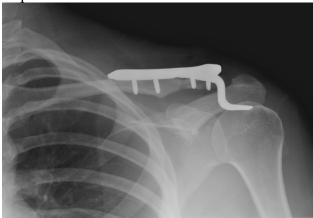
Postoperative (clavicle hook plate) plain radiograph of left shoulder (AP view).
